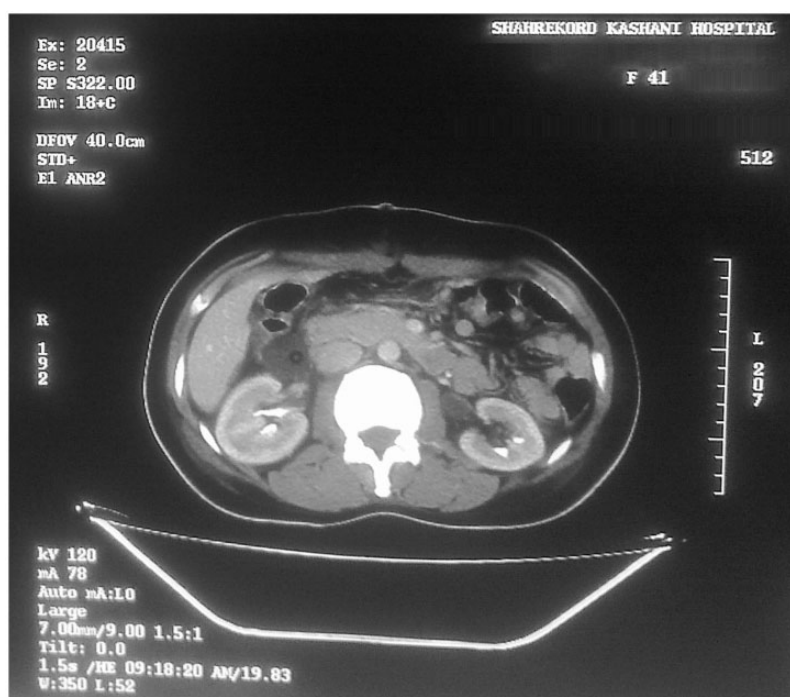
Computed tomography before the operation.
